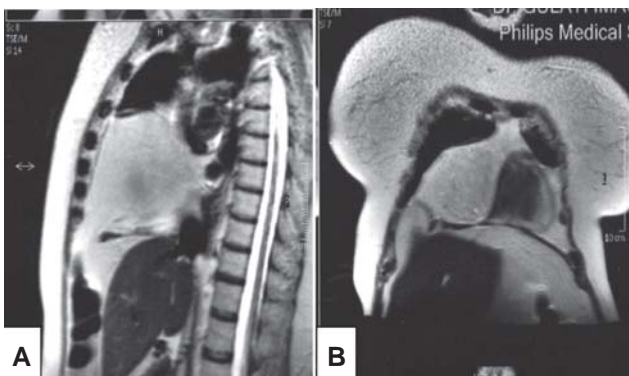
Magnetic resonance imaging of the chest (A) (sagittal image) and (B) (coronal image) showing diaphragmatic defect with omental herniation.
